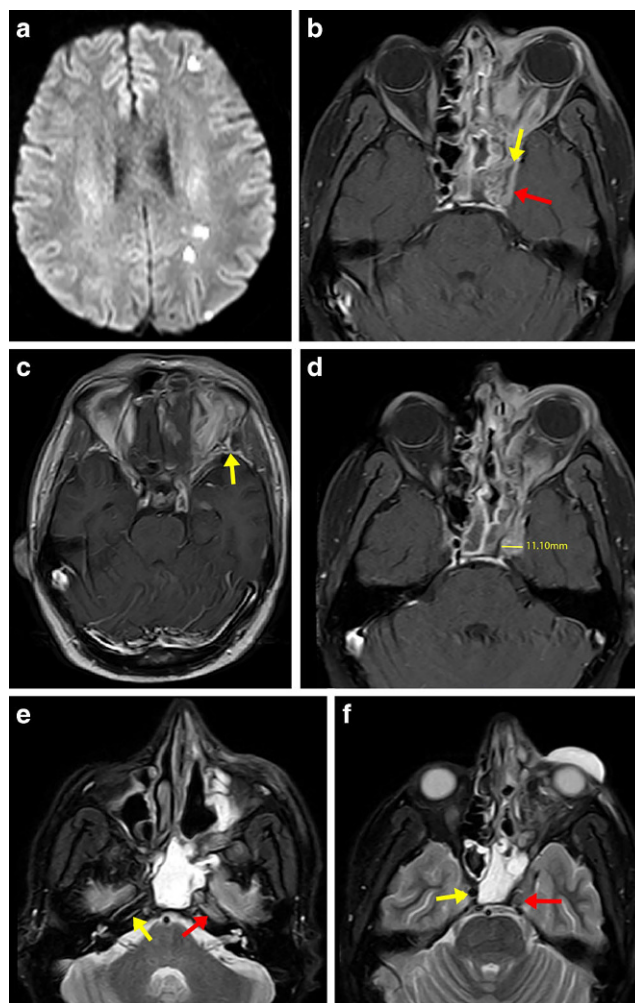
A patient in his late 30s with history of COVID-19 infection three weeks before the admission for hypoesthesia in the left forehead and cheek for two days. It was accompanied by ptosis, proptosis, extraocular movement limitation, and diminished vision. Axial diffusion-weighted imaging (a) demonstrates unilateral ischemic stroke in deep (internal) and cortical (external) watershed zones. Axial post-contrast MRI showing a filling defect (yellow arrow) along with bulging of the lateral wall of the left cavernous sinus (red arrow) (b), dural enhancement in nearby left middle cranial fossa (yellow arrow) (c) and increased cavernous sinus width to 11.1 mm (yellow arrow) (d). Axial T2-weighted fat suppressed MRI showing increased signal intensity in petrosal (e) and proximal cavernous (f) segments of the left internal carotid artery (ICA) (red arrows). The normal right ICA is shown with yellow arrows (e,f)
